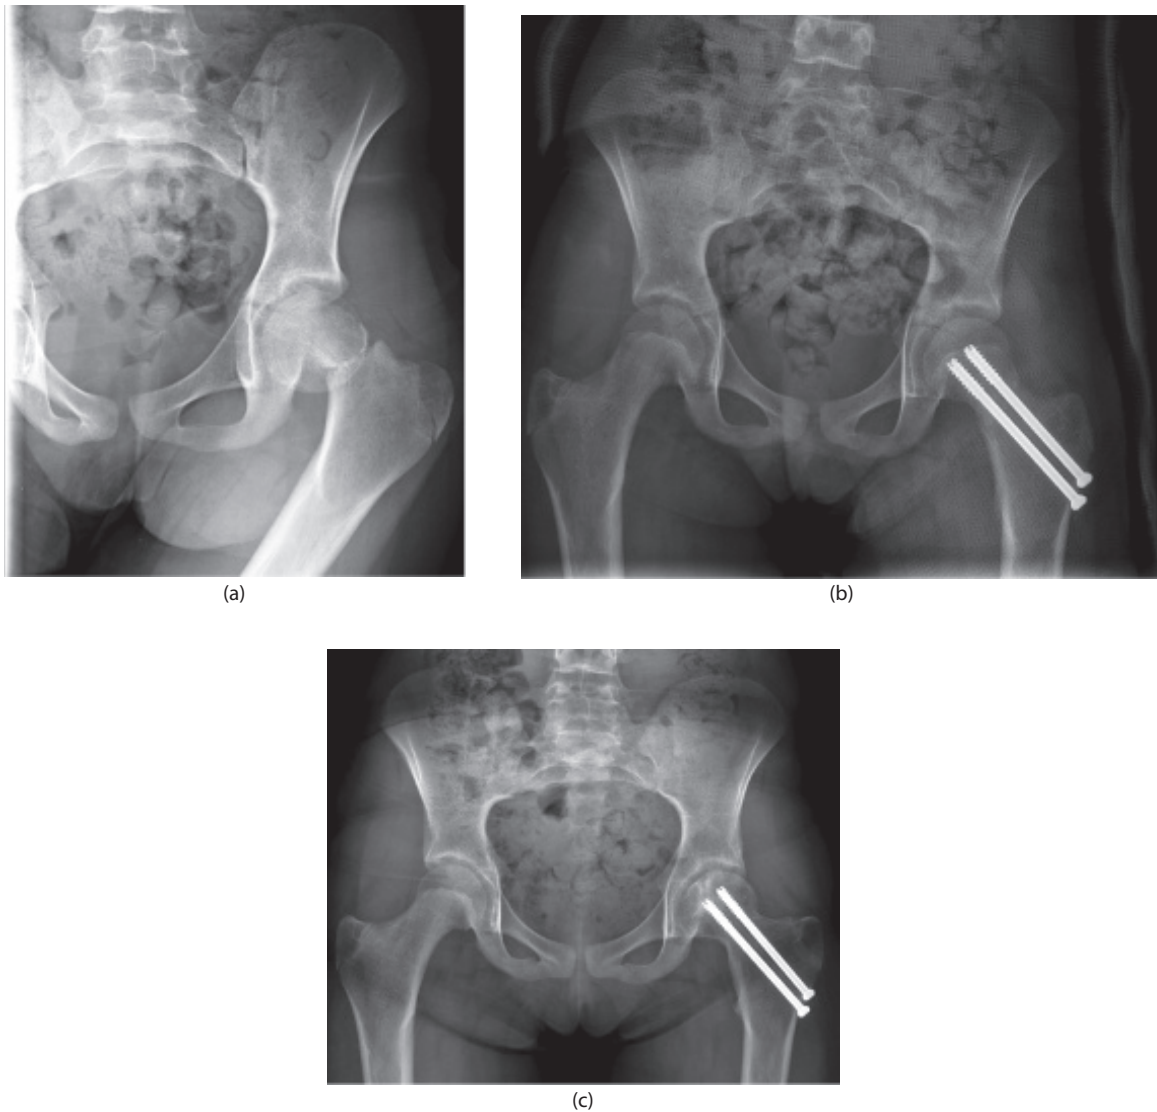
(a) Radiographs of a 9-year-old female with a transcervical femoral neck fracture sustained after falling while playing on a trampoline. (b) Transcervical femoral neck fracture was treated with open reduction and screw fixation. (c) Evidence of avascular necrosis at 2 months after her injury.
